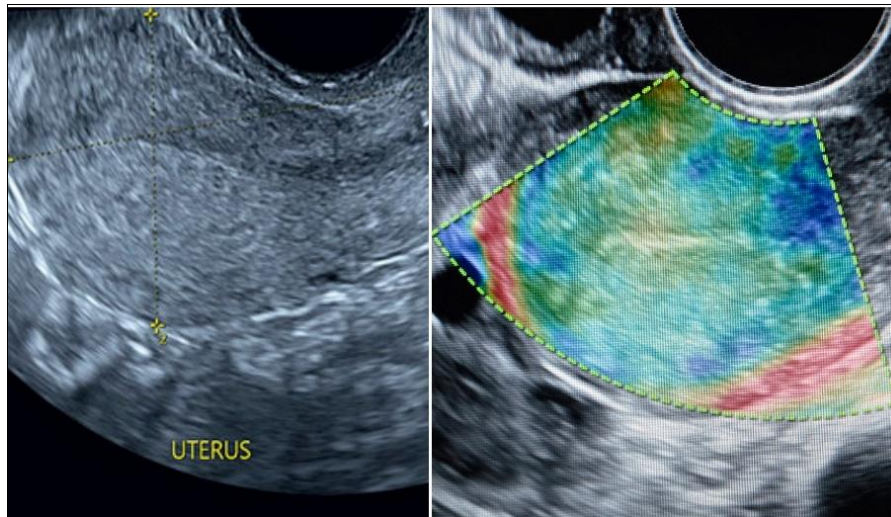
Mid-sagittal transvaginal grayscale ultrasound of Normal uterus(left), Colour strain elastography map of the same plane showing homogeneous tissue stiffness distribution and green to yellow (right) myometrium (bellow).
